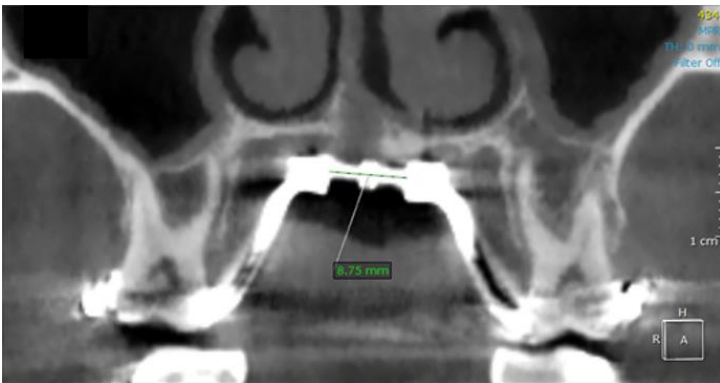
Post-expansion CBCT of a treated patient. Measurement of the distance between the two halves of MSE expansion jackscrew ^{36,44}.
